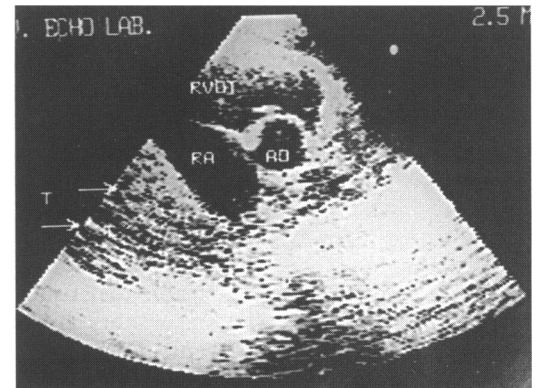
Cross sectional echocardiographic parasternal short axis view (more rightward than view in figure 3) in patient in case 11 showing a huge right atrial thrombus (T) which fills more than half of the dilated right atrial cavity. (RA, right atrium; RVOT, right ventricular outflow tract; AO, aorta).
